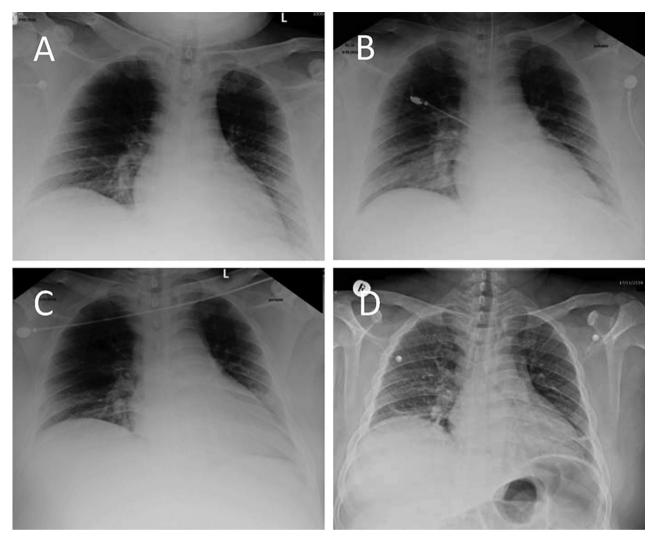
A. Posterior–anterior chest X-ray image demonstrating a slight radiographic sign that suggests interstitial pulmonary edema. B. Supine radiogram demonstrating redistribution of lung circulation from base to middle, suggestive of pulmonary congestion. C. Endotracheal tube inserted after persistent pulmonary congestion. D. Posterior–anterior chest X-ray image showing with normal lung marking and heart size.
